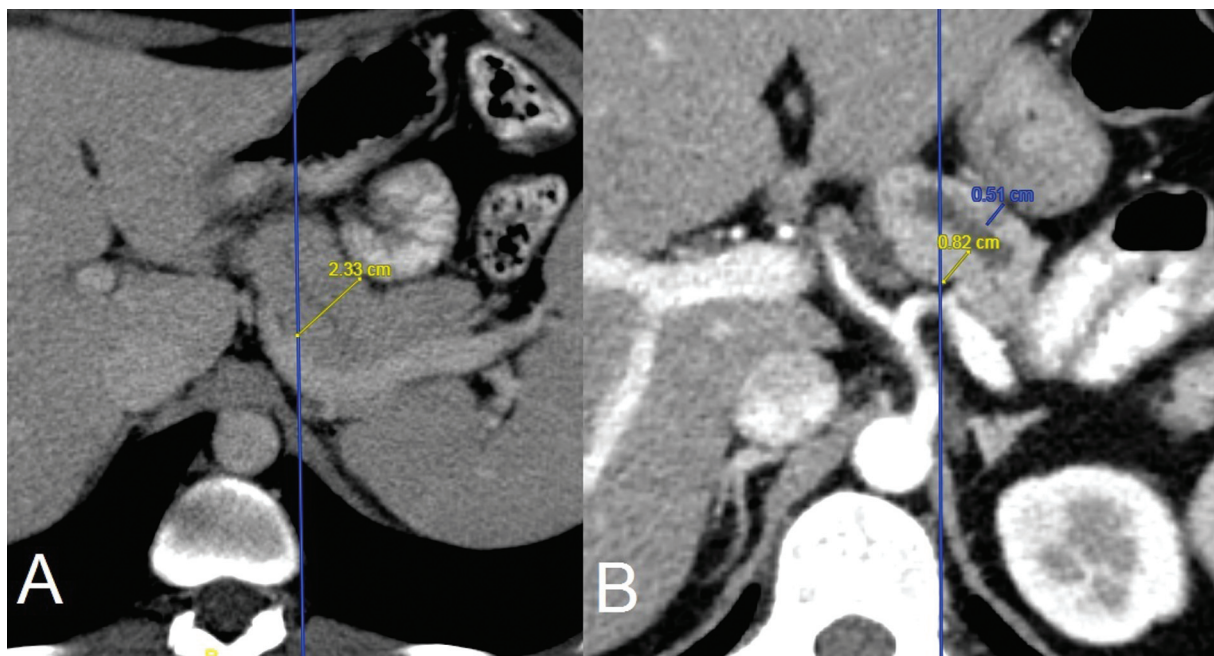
Technique of measuring parenchymal thickness in the mid body of pancreas. (A) Parenchymal thickness is measured in an axial CT section, perpendicular to the pancreatic parenchyma, at the lateral margin of adjacent vertebral body. (B) In patients with dilated main pancreatic duct, duct diameter is excluded from the measurement.
